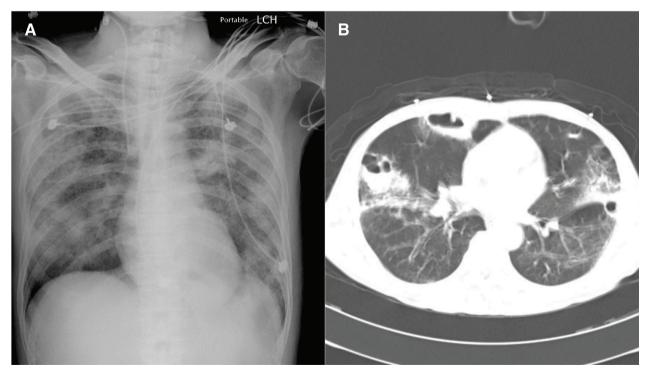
A, Chest radiograph showing mixed infiltration, ground-glass patches and consolidation of the bilateral lung. B, Chest computed tomography showed bilateral multiple cavitary lesions.
